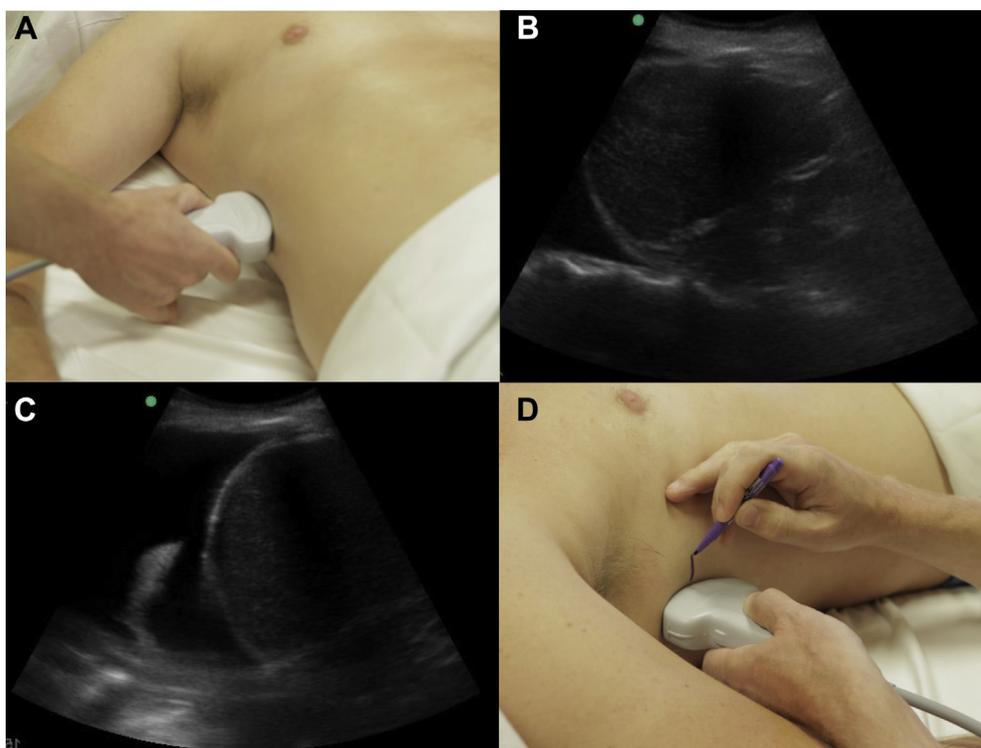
Locate the diaphragm. A, Initial transducer position to achieve the FAST view on the right side. B, The right FAST view, showing the kidney, liver, and diaphragm. C, Bringing the diaphragm to the center of the screen. D, Marking the location of the most cranial aspect of the diaphragm with a skin pen, an optional step that some find helpful. FAST = focused assessment with sonography in trauma.
